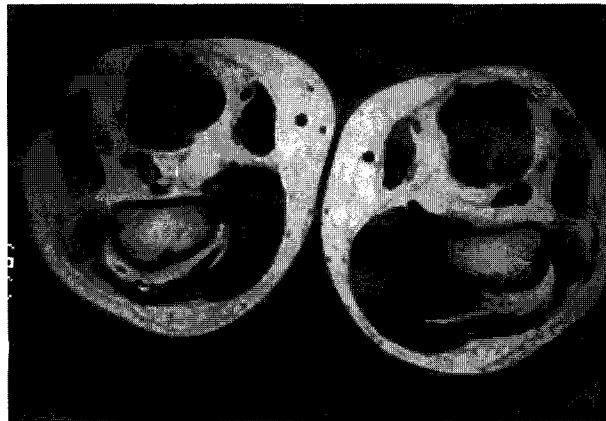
MRI using T1-weighted sequence showing medial surface tumour without obvious medullary invasion occupying approximately 30% of the circumference of the cortex.*
